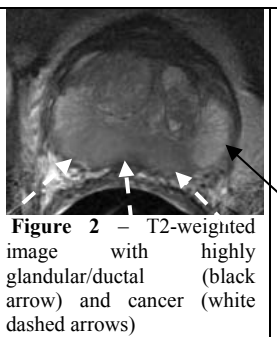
T2-weighted image with highly glandular/ductal (black arrow) and cancer (white dashed arrows)
